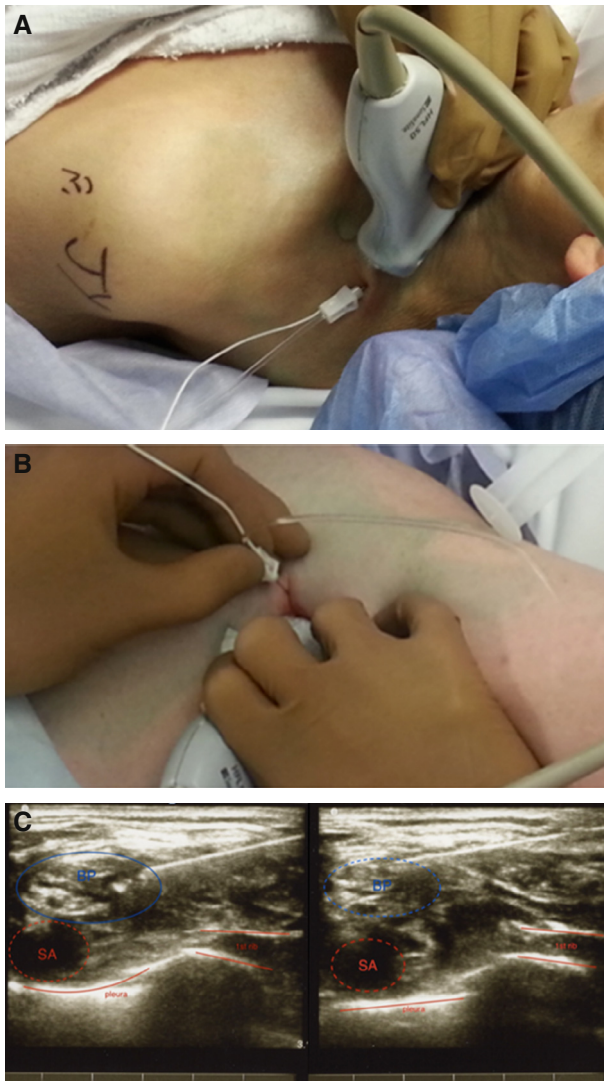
(A) Interscalene nerve block performed under ultrasound guidance. (B) Axillary nerve block performed under ultrasound guidance. The needle is introduced from anterior near the axillary fold with the arm abducted. (C) Ultrasound image of the needle being introduced around the brachial plexus for anesthetic injection. BP, brachial plexus; SA, subacromial artery.
